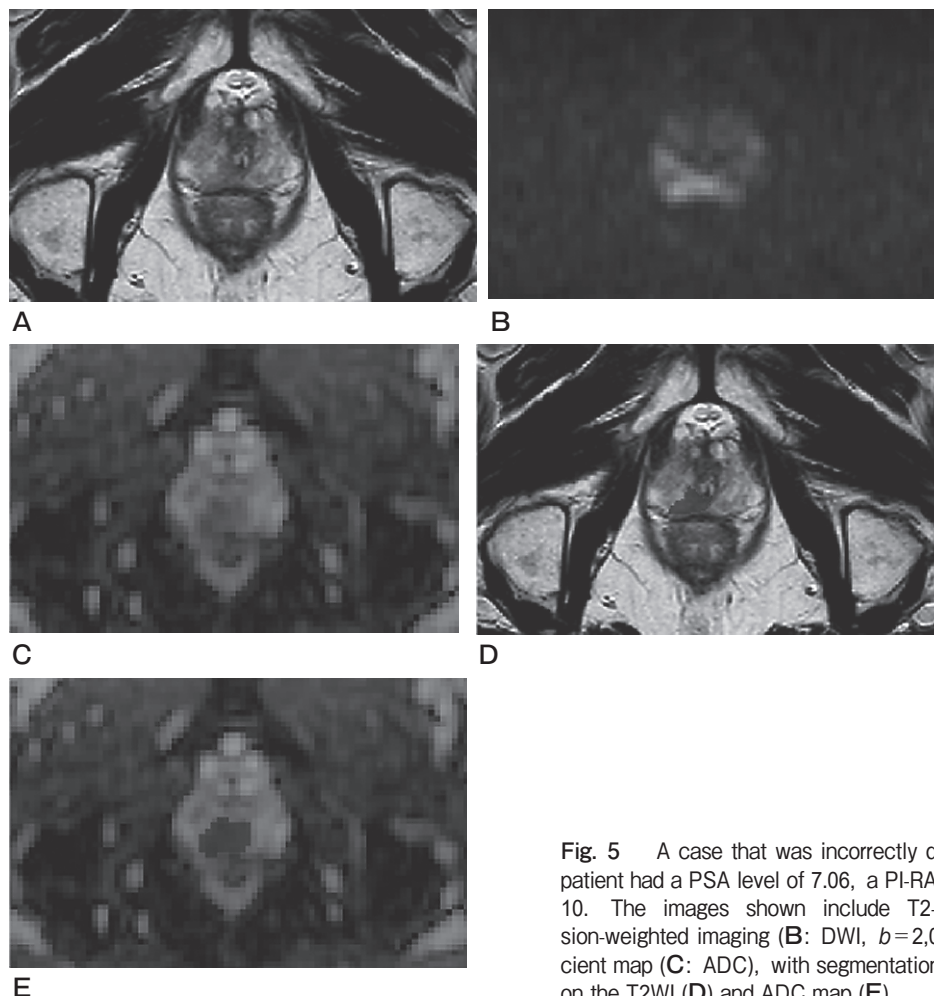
A case that was incorrectly diagnosed by the PI-RADS model. The patient had a PSA level of 7.06, a PI-RADS score of 3, and a Gleason score of 10. The images shown include T2-weighted imaging (A: T2WI), diffusion-weighted imaging (B: DWI, $b=2,000$), and the apparent diffusion coefficient map (C: ADC), with segmentations of the lesion highlighted in dark gray on the T2WI (D) and ADC map (E).
